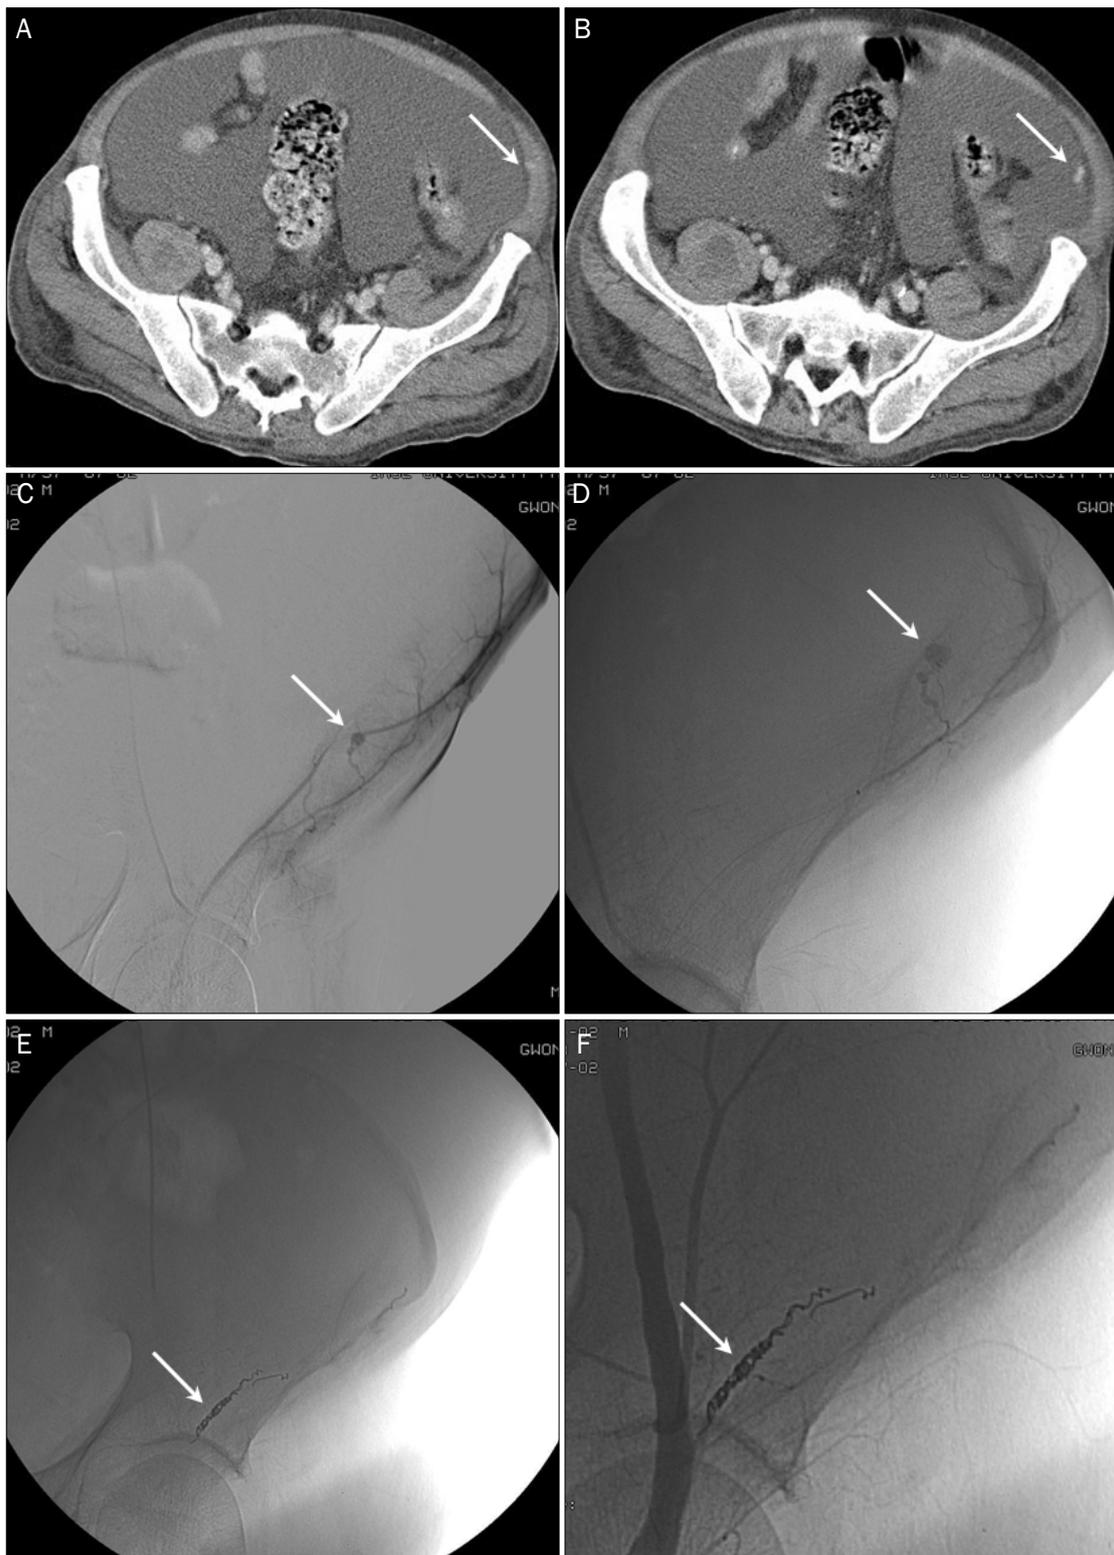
The findings of abdominal CT and percutaneous iliac angiography. (A, B) CT shows active bleeding (arrow) on the left lower lateral peritoneum. (C, D) Percutaneous iliac angiography shows leakage of contrast media (arrow) from the branch of left superficial circumflex iliac artery. (E, F) After embolization with microcoils (arrow), no evidence of bleeding is seen the left iliac angiogram. CT, computed tomography.
